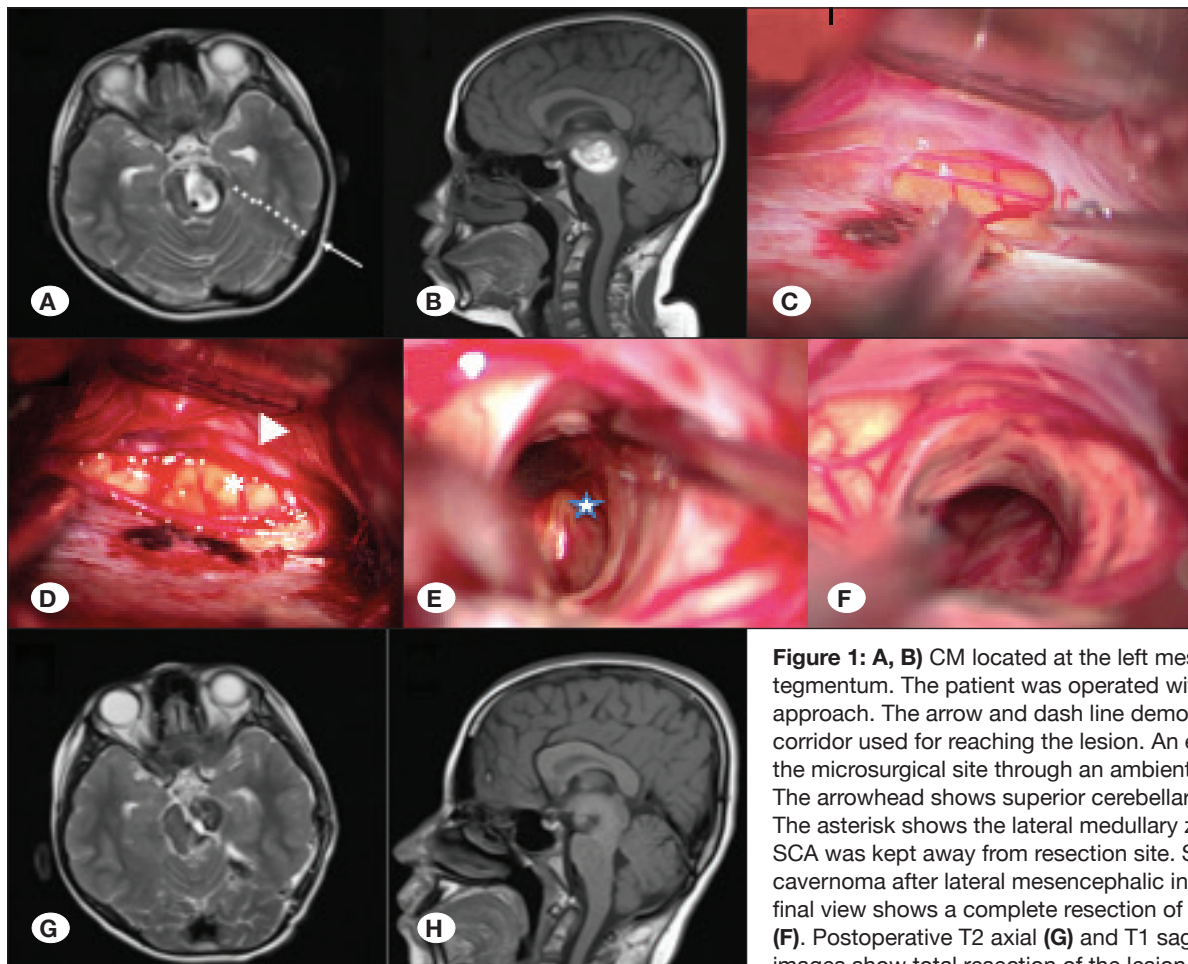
A, B) CM located at the left mesencephalic tegmentum. The patient was operated with a subtemporal approach. The arrow and dash line demonstrate the corridor used for reaching the lesion. An entry view of the microsurgical site through an ambient cistern (C, D). The arrowhead shows superior cerebellar artery (SCA). The asterisk shows the lateral medullary zone (LMZ). The SCA was kept away from resection site. Star shows the cavernoma after lateral mesencephalic incision (E). The final view shows a complete resection of the cavernoma (F). Postoperative T2 axial (G) and T1 sagittal (H) MR images show total resection of the lesion.
